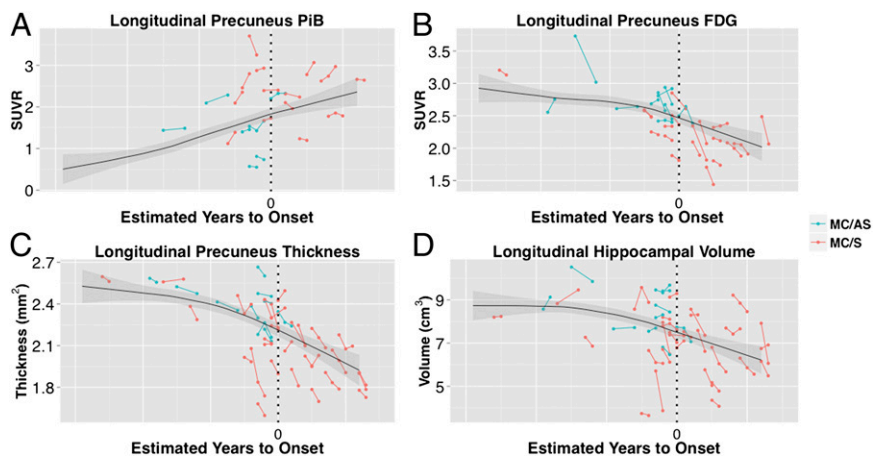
Longitudinal data for PiB (A), FDG (B), cortical thickness (C), and hippocampal volume (D). Asymptomatic (CDR 0) participants are shown in blue. Symptomatic participants (CDR 0.5 or higher) are shown in red. Overlaid on each plot is the LOESS estimated cross-sectional trajectory for carriers with 95% confidence intervals of the mean in gray. Note the generally steeper longitudinal vs. cross-sectional slope in symptomatic participants. The x axis is unlabeled and only carriers are shown to protect the mutation status of each participant.
